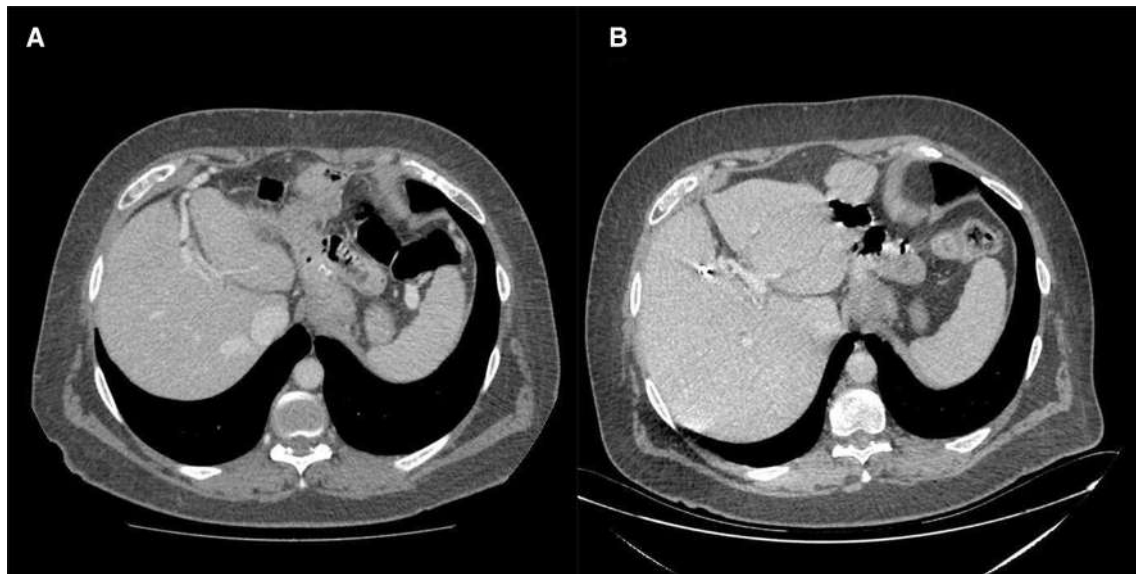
a Computed tomography (CT) scan with intravenous contrast (portal phase) before recanalization in participant #2 demonstrates a small volume, ischemic liver with para-umbilical vein recanalization
